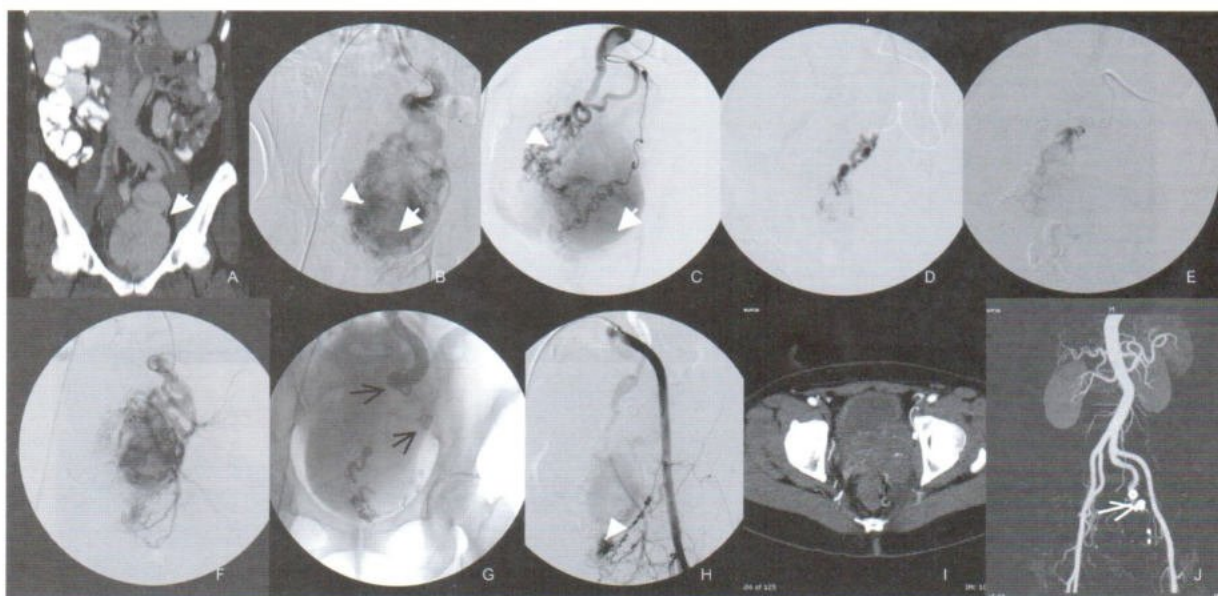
Angiogram of the AVM in the patient 1: (A): coronal MIP of initial CT abdomen showed abnormal venous lake (arrow) in pelvic cavity. (B): angiogram and (C): superselective angiogram of left internal iliac artery showed type AVM with nidus (arrowheads) and large venous pouch (arrows). (D, E): superselective embolization with glue. (F): pre-embolization of final angiogram showed 50% devascularization. (G): multiple coil embolizations with complete occlusion of the left internal iliac (thin arrows). (H): 90 % devascularization with minimal residual nidus (arrowhead) and arterial feeding from branch of left external iliac artery. (I) axial and (J) 3D reformat of the CT angiogram after six years of embolization showed total thrombosis of venous pouch and no recurrence of AVM. Note coils (thin arrow).
